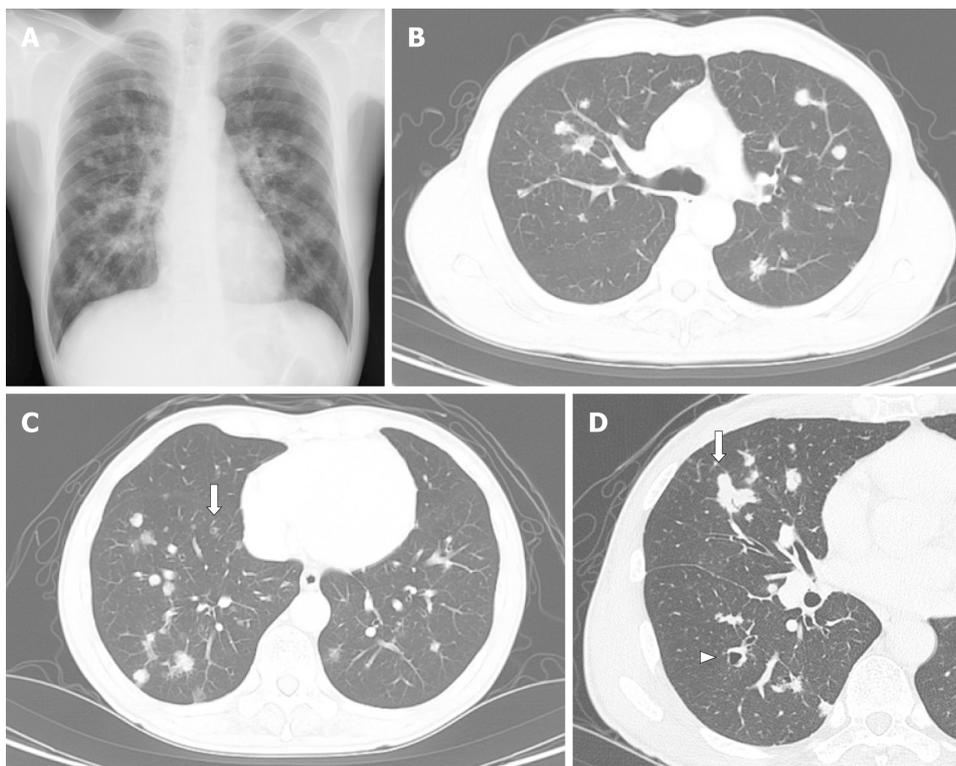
Radiological findings at the initial diagnosis. A: Chest X-ray at the diagnosis showed multiple nodules in bilateral lung fields; B and C: Chest computed tomography showed multiple nodules, adjacent to the pleura or bronchus, predominantly in the right lower lobe. Some small nodules showed cystic formation (arrow); D: Largest nodule was in the right middle lobe; 22 mm dia. (arrow). Arrowhead: A dilated bronchus, but not a cystic nodule.
